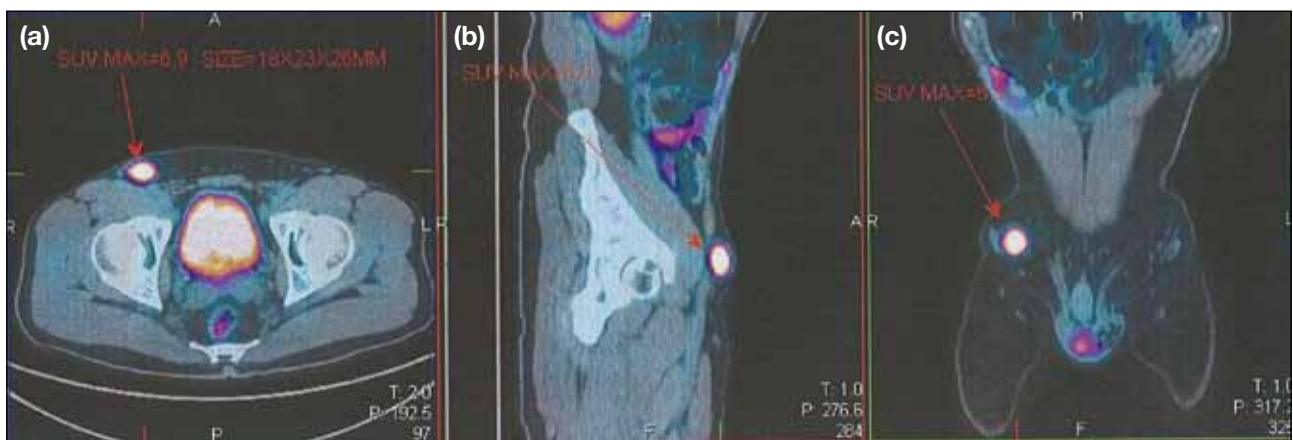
(a) Axial, (b) sagittal, and (c) coronal positron emission tomography / computed tomography fusion images showing a 1.8 x 2.3 x 2.6-cm hypermetabolic lymph node in the right groin. Maximum standardised uptake value = 6.9.
